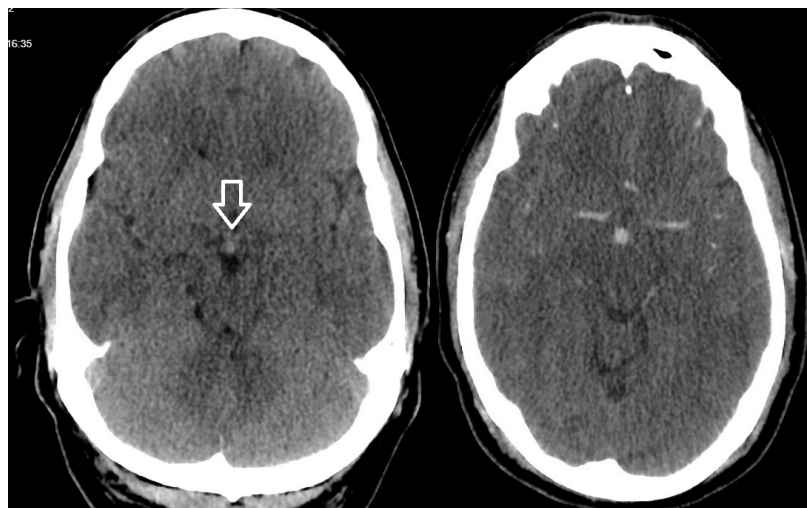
Aneurysm. A 50-y/o patient with idiopathic seizure disorder as a teenager for a year, who complained of multiple syncopal events that led to a motor vehicle collision and the discovery of a basilar aneurysm. Minimal hyperdensity is seen in the basilar artery on non-contrast CT (white arrow), becoming more noticeable on CT angiography (right image).
